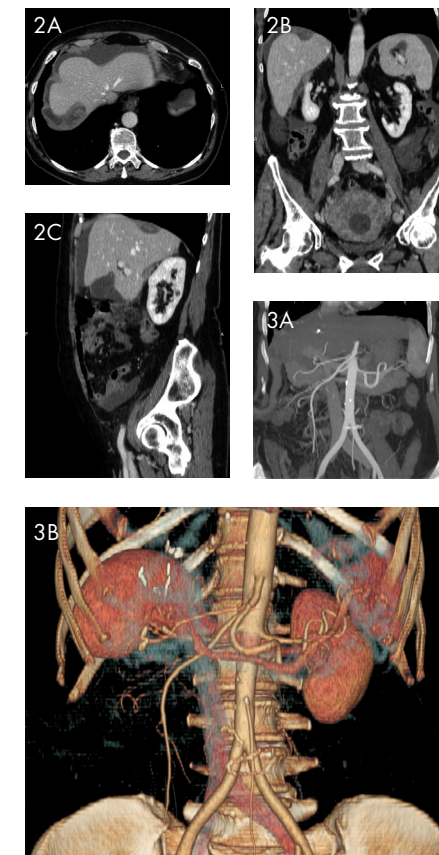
a,b,c. Multiplanar (MPR) CT reconstructions of an ovarian cancer patient, showing a hepatic lesion on the axial image (a), which is clearly located on the liver surface on the coronal (b) and sagittal (c) images, thus making the patient a stage III instead of stage IV
